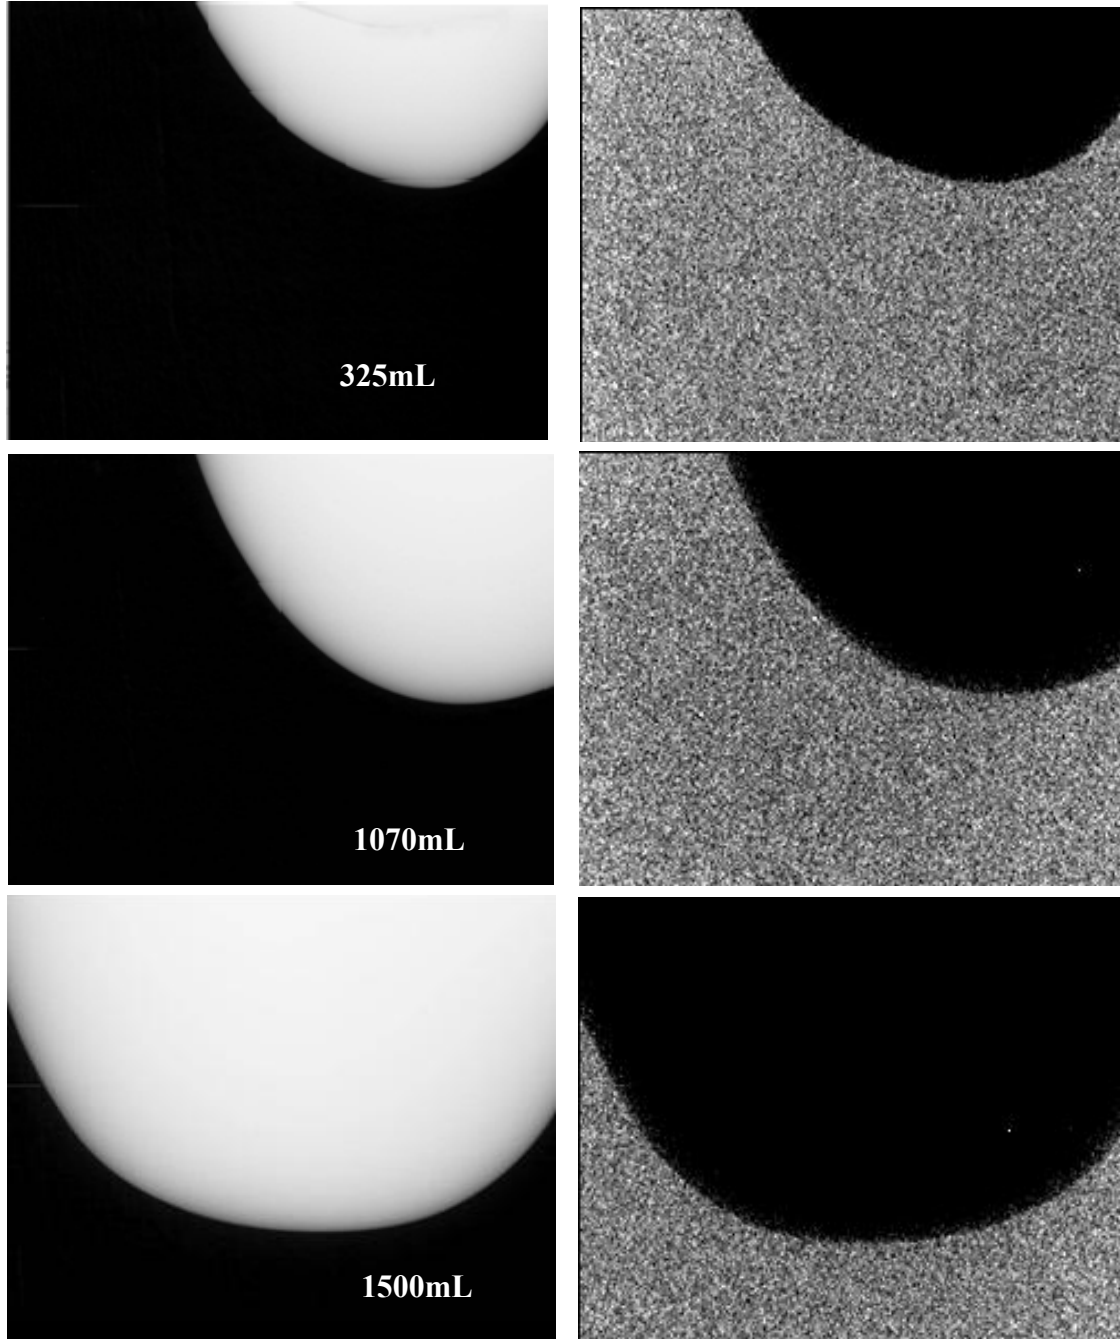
(Left) Sample projections of the three breasts acquired in position A. X-ray exposure is kept constant at 2.5 mAs. Dark areas indicate areas of high detector exposure. (Right) Standard deviation images of the three breasts exhibit no obvious spatially-dependent noise due to emission contamination. The contrast has been enhanced to highlight variations in the image. The coefficients of variation in the background regions for the standard deviation images are 10.1%, 10.89, and 11.1% for the 325, 1070, and 1500 mL breasts, respectively; the coefficients of variation in the breast regions are 8.1%, 13.2%, and 12.1% for the 325, 1070, and 1500mL breasts, respectively.
